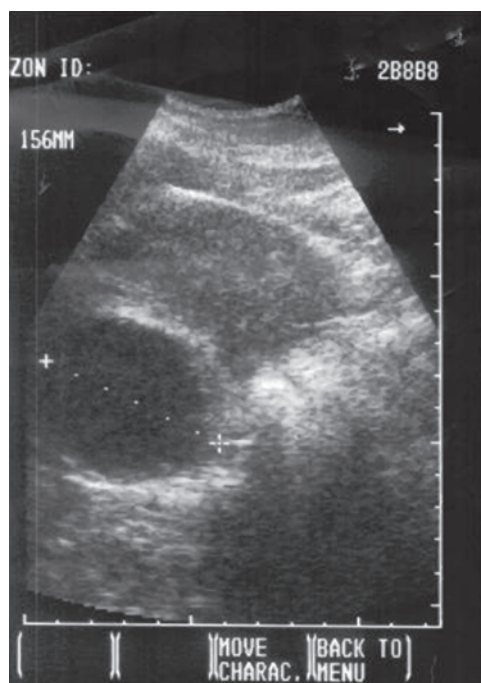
Abdominal ultrasonography obtained at the level of the right adrenal fossa shows a thick-walled (8 mm), well-defined anechoic cystic mass, 57 mm in diameter.
